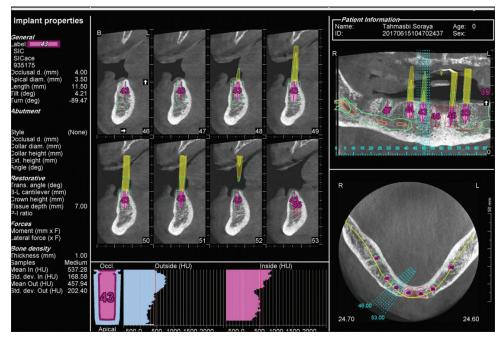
Radiographic view of the areas intended for implant placement and the grayscale value of the bone.
